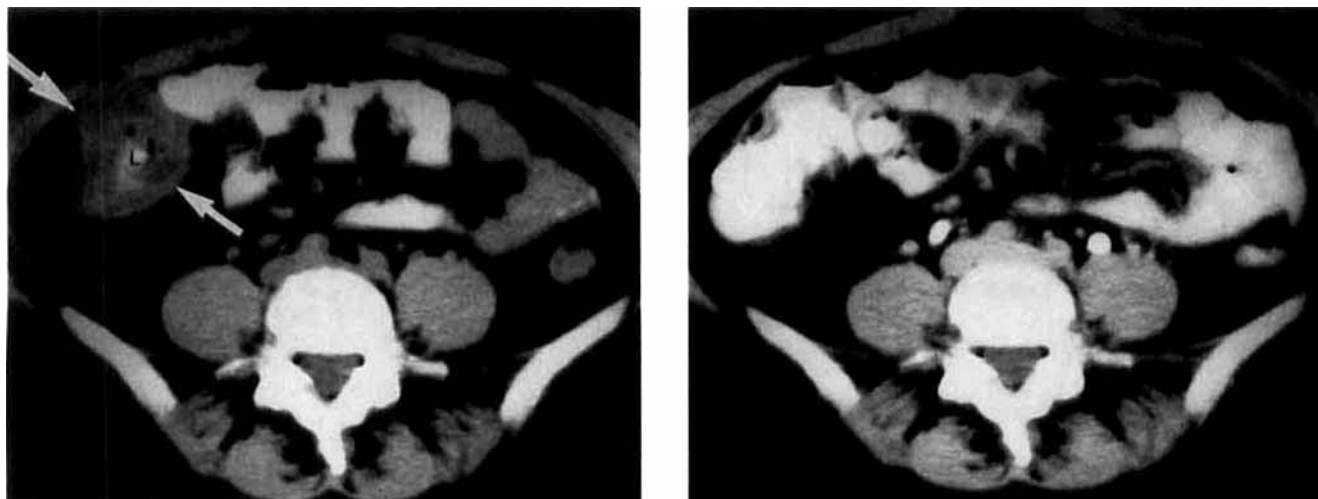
Radiologic studies in Case 2. (Left) Abdominal CT scan (Day 11, oral contrast) demonstrating marked thickening of the cecal wall (arrows) and narrowing of lumen (L). (Right) Abdominal CT scan (Day 17, oral contrast) showing almost complete resolution of cecal wall thickening and a lumen of normal width.
